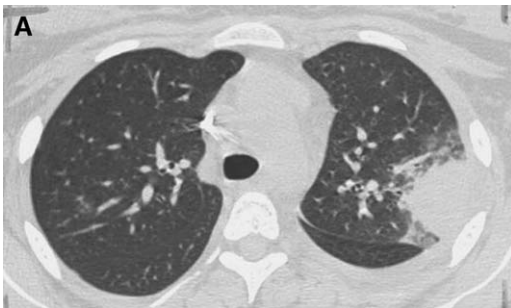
CT scan of early invasive aspergillosis (A) and later after the air crescent has developed (B).
